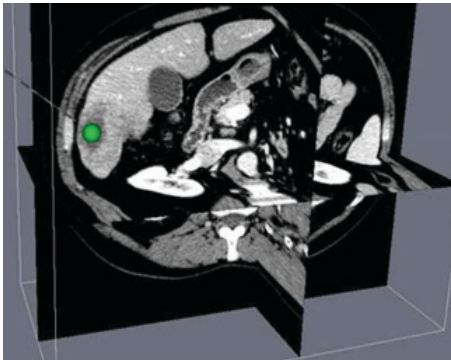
Patient CT image displayed in the virtual exterior view. A green sphere target placed by the user is visible.
